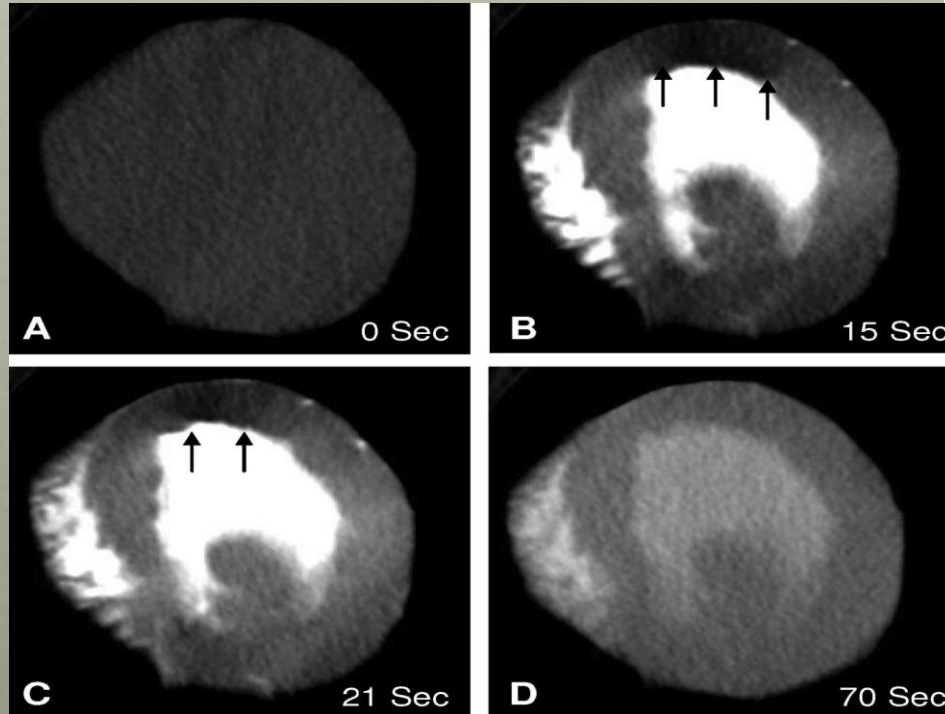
64-Slice CT Scan 21 Min After Left Anterior Descending Coronary Artery Reperfusion
